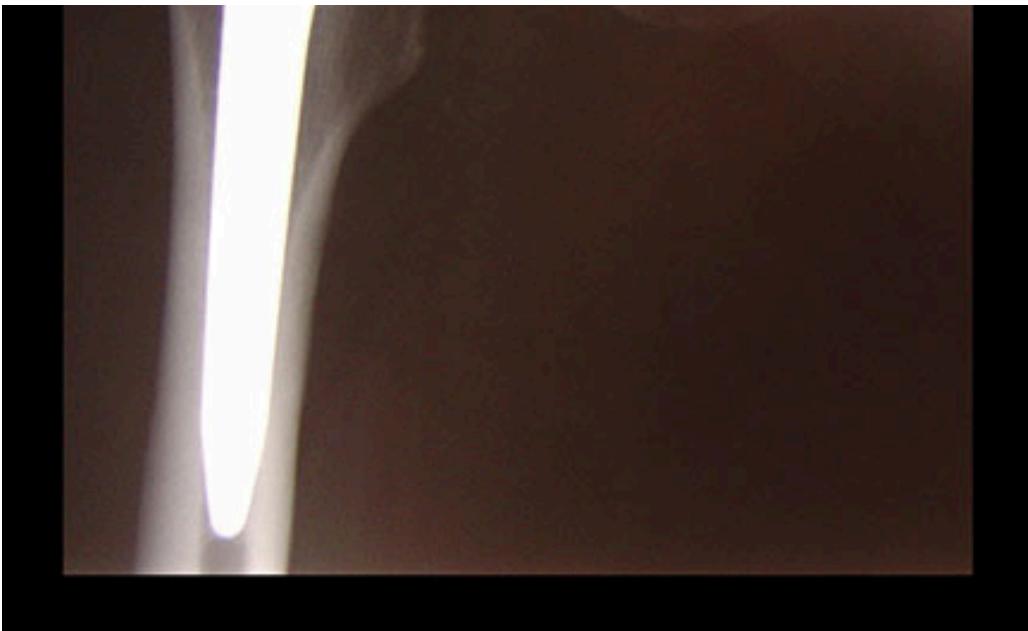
a) Titanium femoral component (Zweymüller) with a ceramic head (Al_2O_3) used in Norway between 1985 and 1988. b) X-ray image 18 years after insertion of the prosthesis in a 55-year-old woman. Stable, osseointegrated titanium femoral component with a ceramic head.
